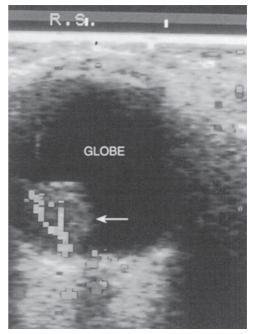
Transverse color Doppler image of the eye in a patient with choroidal malignant melanoma (*arrow*). Blood flow is detected from vessels in the tumor.
